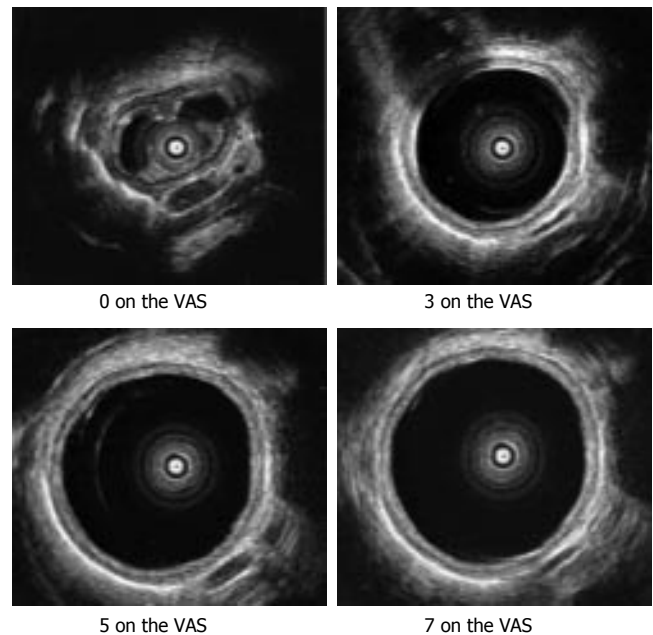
Transversal ultrasonographic images of the esophagus at different sensory perception levels. The esophagus is fairly circular at 3 on the visual analogue scale. The numbers refer to the sensory intensity at a visual analog scale with 5 as the pain threshold.
